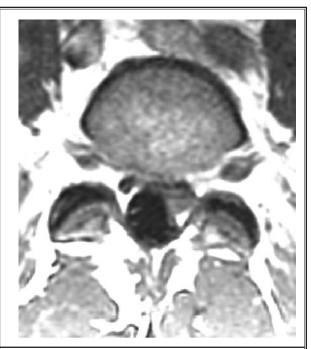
Post-treatment T1 weighted axial MRI image of the same lesion at L5-S1.
